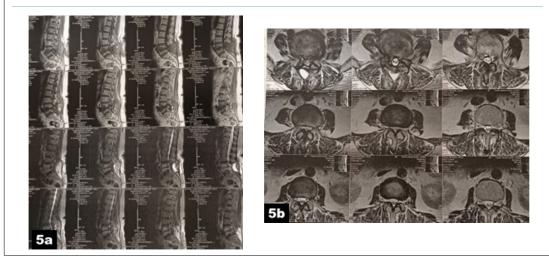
Post-Operative Sagittal and Axial Lumbar Spine MRI at 6-months Follow-up, (a & b) both T1 and T2-Weighted Sagittal and Axial Images after Excision of the Pseudomeningocele, the Small Hyperintense Mass is Probably Free Fat Graft
